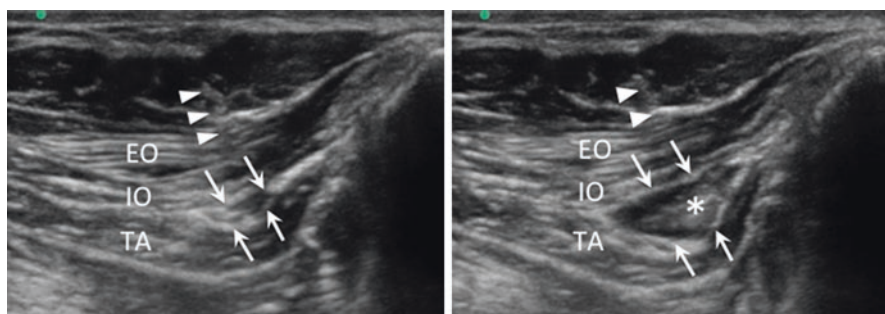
Sonography showing the needle insertion. The needle was inserted out of plane and indicated by arrowheads. The injectate was indicated by * within the fascia expansion (arrows). EO external oblique, IO internal oblique, TA transversus abdominis. (Reprinted with permission from Philip Peng Educational Series)
